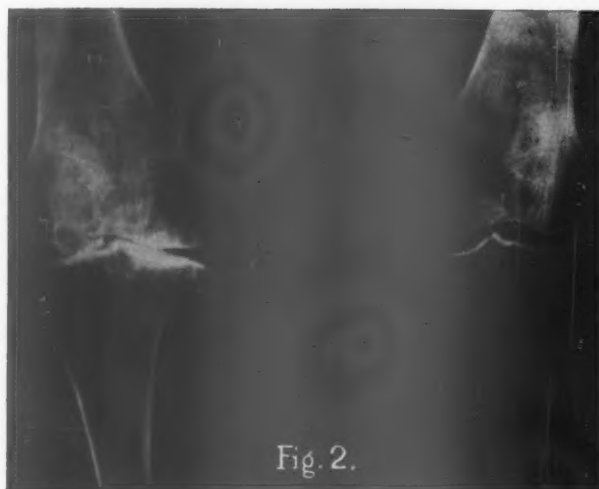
Radiographs of a patient, aged 66, who has been suffering from anaemia perniciosa for ten years and has had a strong myelosis funicularis for the last five years. There are severe changes of osteoarthritic type, especially in the right knee. Note also the appearance of osteophytes, marked narrowing at the interarticular spaces, and loose fragments in the vicinity of joint surfaces.
